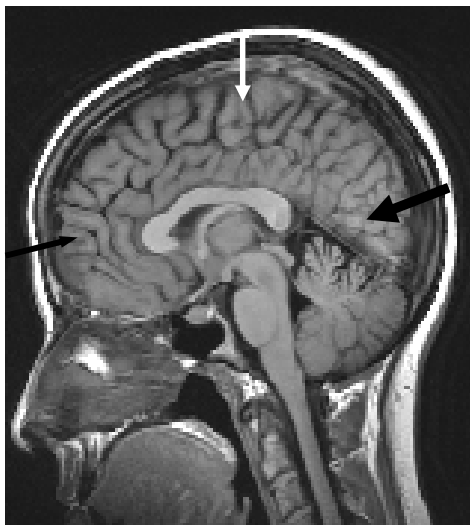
Magnetic Resonance Image Showing the Frontal Lobe, Parietal Lobe and Occipital Lobe (Small Black Arrow Depicts Frontal Lobe, Large Black Arrow Depicts Occipital Lobe and Large White Arrow Depicts Parietal Lobe). Adapted from “Magnetic Resonance Imaging Cross-Sectional Anatomy Technologist Educational Program” by L. Hoisington and S. Fedewa, 2007, p. 23.
